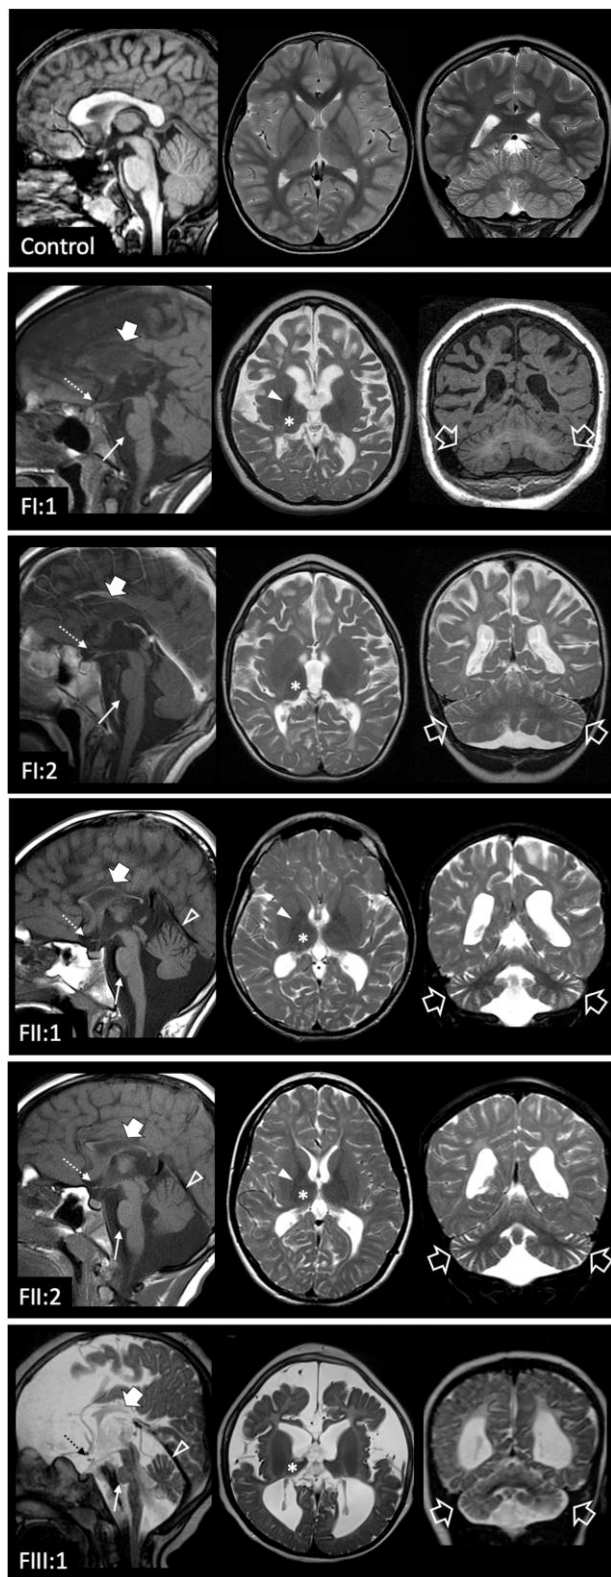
Neuroimaging findings. Brain MRI studies of a control subject performed at 9 years of age for comparison, and of the patients performed at 9 years (Patient FI:1), 7.7 years (Patient FI:2), 13 years Patient FII:1), 12 years (Patient FII:2) and 3 years of age (Patient FIII:1). In the patients, sagittal T₁- or T₂-weighted (left), axial T₂-weighted (middle) and coronal T₁ or T₂-weighted images (right) reveal mild-to-severe cerebral atrophy with reduced white matter volume and enlarged subarachnoid spaces in all cases. There is diffuse T₂ hyperintensity of the cerebral
